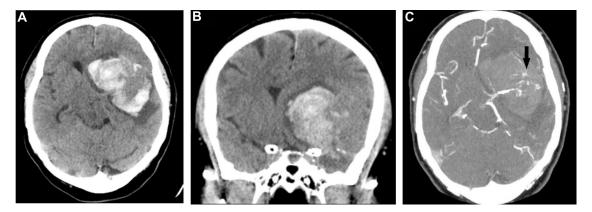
Preoperative CT scan showing the extent of the hemorrhage in the (A) axial and (B) coronal plane as well as (C) marked vasculature in the lateral part of the hematoma (black arrow), masking the underlying tumor.
